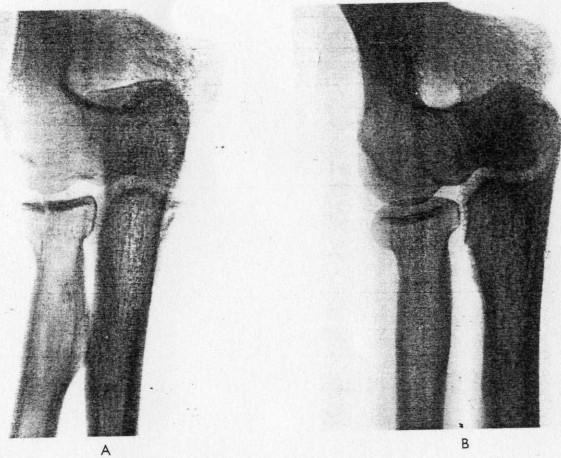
Case N. P. Anteroposterior radiographs showing a typical Type 1 fracture of the radial head. A, The original radiograph; B, The subsequent X-ray photograph taken 30 months later. The fracture has united and the elbow-joint appears normal. The function of the joint was full.
